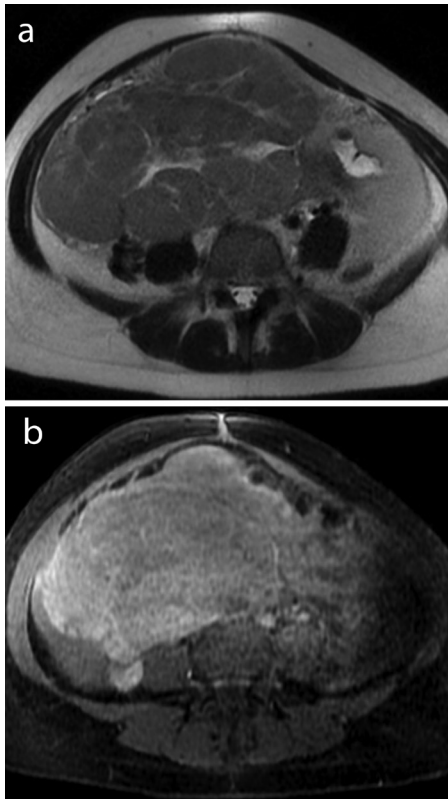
Axial T2WI (a) and gadolinium-enhanced image (b) revealing a bilateral primary ovarian B-cell lymphoma with high-SI septa on T2WI and progressive and homogeneous enhancement. T2WI, T2-weighted imaging; SI, signal intensity.
